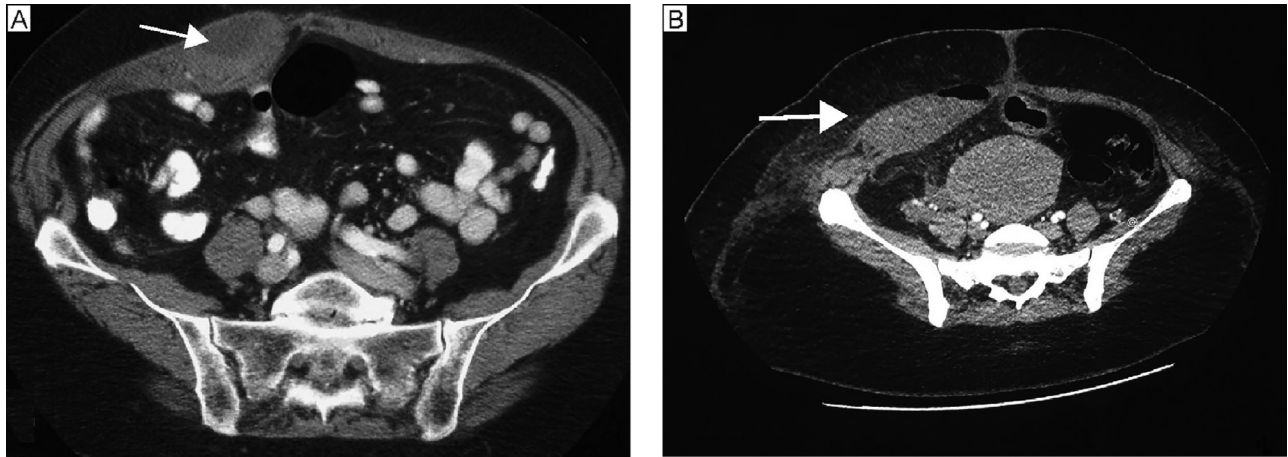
Postoperative cross-sectional CT scans of the RSH (white arrows) in the studied case. (A) Day-1 scan. (B) Follow-up scan.
